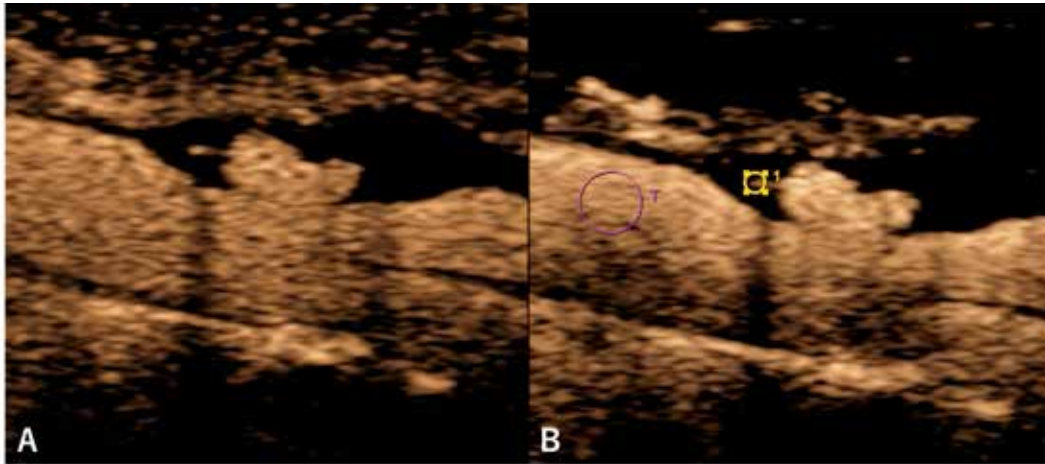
Contrast-enhanced ultrasonography of carotid plaque.
